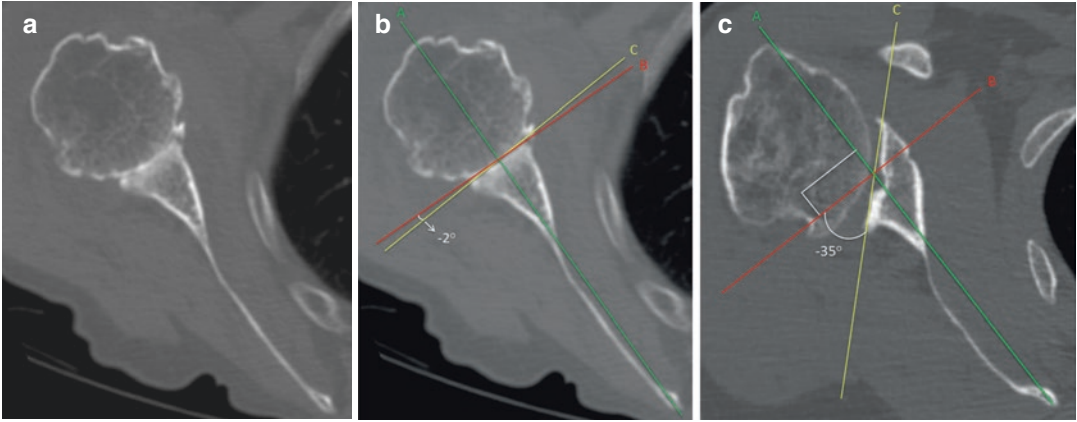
(a) Axial CT of severe glenohumeral osteoarthritis. (b) The same image as A with measurement of glenoid version. To measure glenoid version draw a line from the medial border of the scapula to the center of the glenoid (line A). Draw a line perpendicular to this line (line
